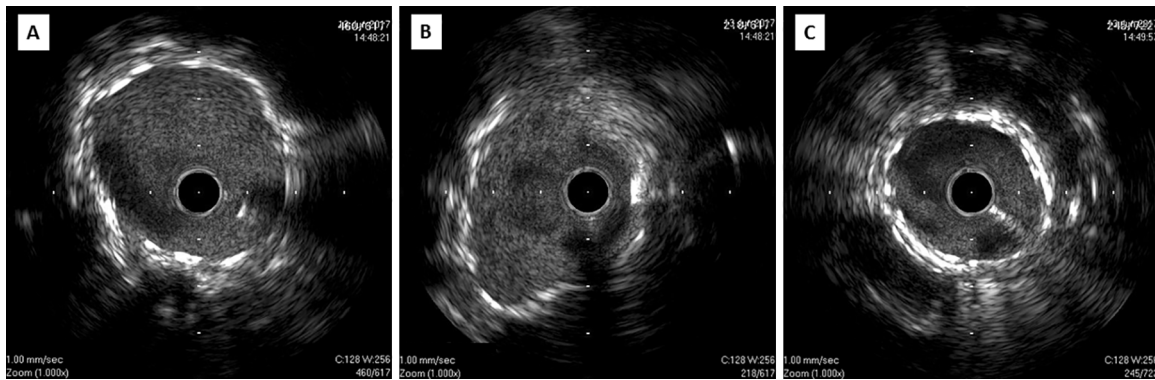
Cross-sectional intravascular ultrasound images in culotte bifurcation two-stenting. (A) Distal left main trunk. (B) Proximal left anterior descending artery. (C) Proximal left circumflex artery.
